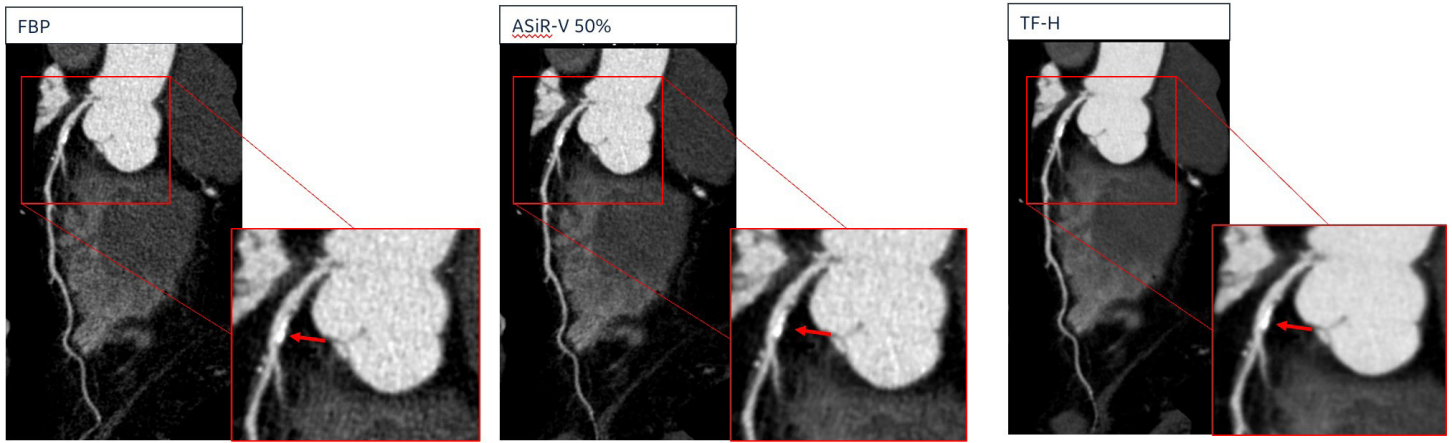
Comparison of CT image reconstruction algorithms in 80kVp CCTA. A 59-year-old male patient (BMI 26.9 kg/m², HR: 69 bpm) received a CCTA exam (80kV, 240-305 auto mA, 14cm detector coverage, 0.28s/rot, 75%-80% exposure window), and images were reconstructed with FBP, ASiR-V 50% and TF-H. LAD image shows the calcified plaque (red arrow). Compared to FBP and ASiR-V, TF-H demonstrates the clearer boundary distinction between the vessel and calcified plaque with less beam hardening artifacts. Courtesy of Dr. Wenjie Yang, the Department of Radiology, Ruijin Hospital, Shanghai, China.
